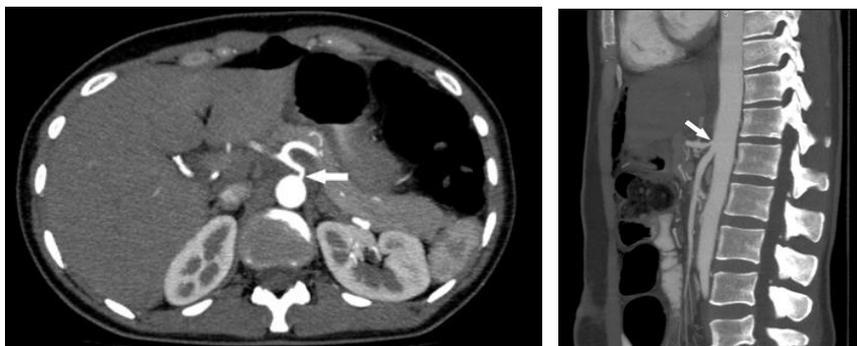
Corrected compression of the celiac artery orifice (white arrows) and elevated calibration distally at postoperative CT angiography. (a) Axially, (b) sagittally reconstructed image.
